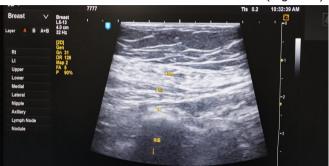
(Original) ultrasound image of pectoral region.
